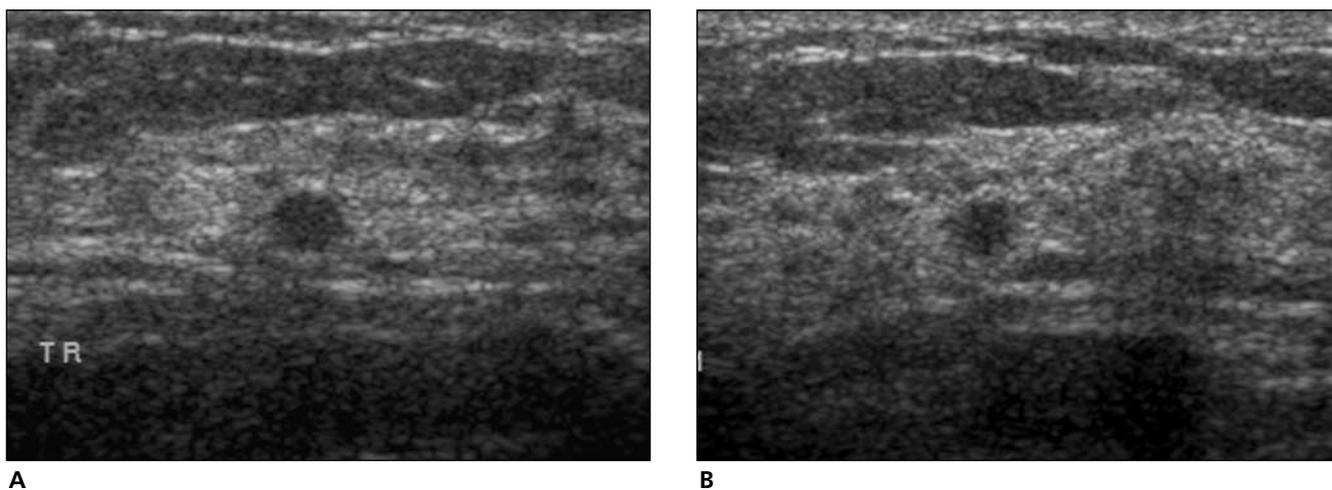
Focal fibrosis in a 48-year-old woman. A mammogram (not shown) revealed a heterogeneously dense breast without remarkable findings. The patient had a history of contralateral breast carcinoma 2 years previously. Transverse (A) and longitudinal (B) sonograms reveal a round, isoechoic nodule with a microlobulated margin. We suggested it was a category 4A lesion, and focal fibrosis was diagnosed by a sonographically guided core biopsy. The lesion was diminished in size on follow-up sonographic examination after 26 months.
